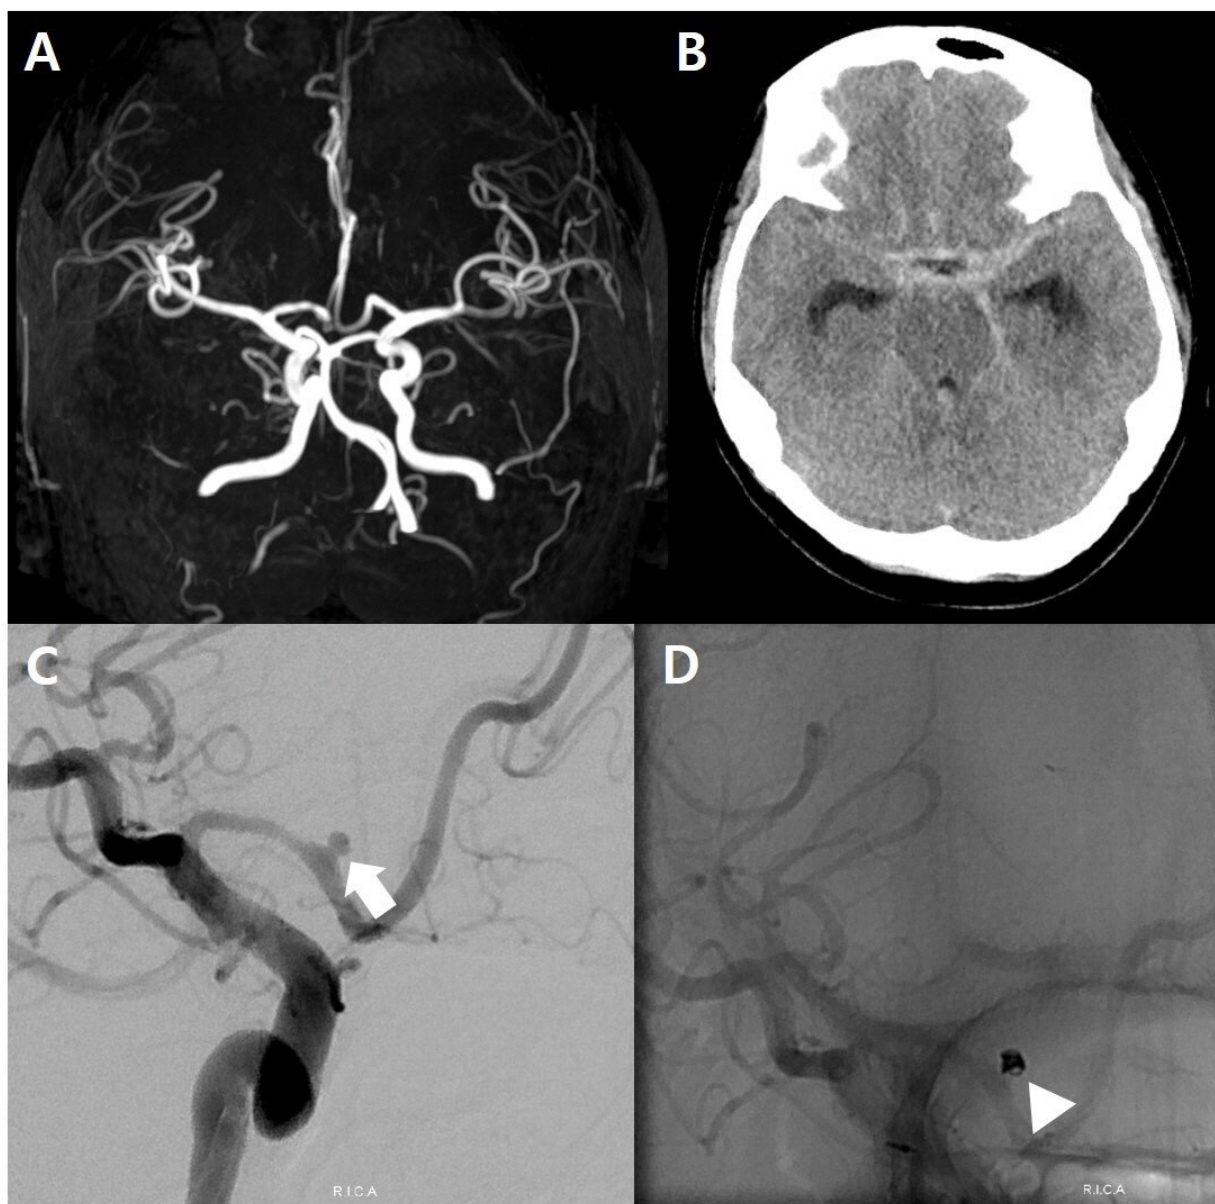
Peri-operative brain imaging of the patient. (A) An unremarkable finding on brain magnetic resonance angiography performed on the third day after acute exacerbation of chronic migraine. (B) Subarachnoid hemorrhage was diagnosed on brain computed tomography performed on day 8 after acute exacerbation of chronic migraine. (C) A small intracranial aneurysm detected in the A1 portion of the right anterior cerebral artery by transfemoral cerebral angiography (arrow). (D) Endovascular coil embolization was successfully performed (arrowhead).
